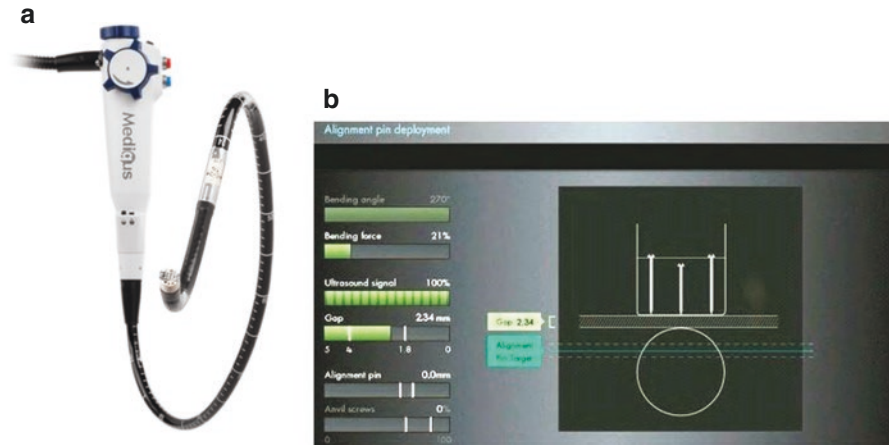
The Medigus Surgical Ultrasonic Endostapler device (MUSE™). (Courtesy of Medigus, Omer, Israel). (a) The MUSE™ device; (b) the console connected with the endostapler, containing a controller for the camera, ultrasonic range finder, and various sensors (bending angle, bending force, alignment pin, anvil screws, gap)
